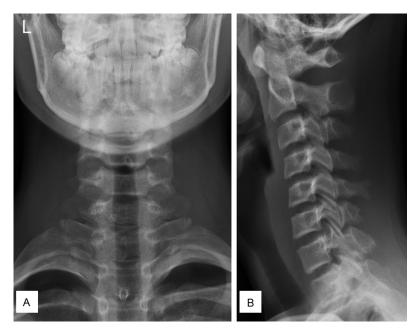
At the five-year and five-month follow-up the postoperative anteroposterior (A) and lateral plain (B) radiographs demonstrate a stable sagittal alignment of cervical spine with no evidence of recurrence.
